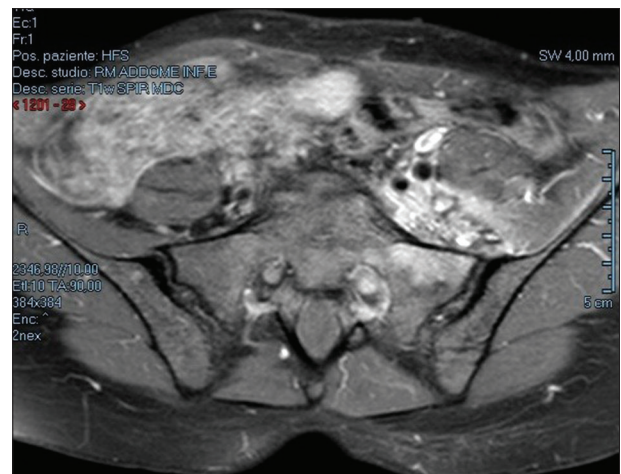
Contrast-enhanced T1-weighted MRI sequence showing a retroperitoneal mass infiltrating left psoas and iliac muscles, L5-S1 left conjugation foramen with edema of spongy bone
